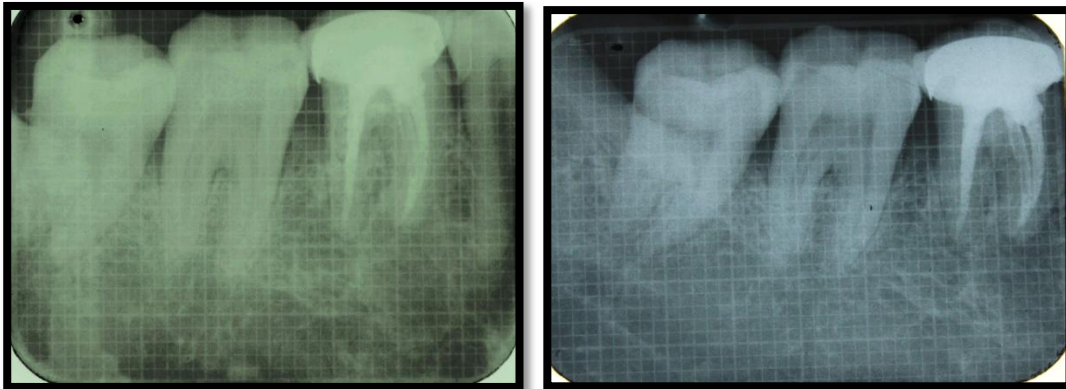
Radiographic view At Baseline and at 6 months
